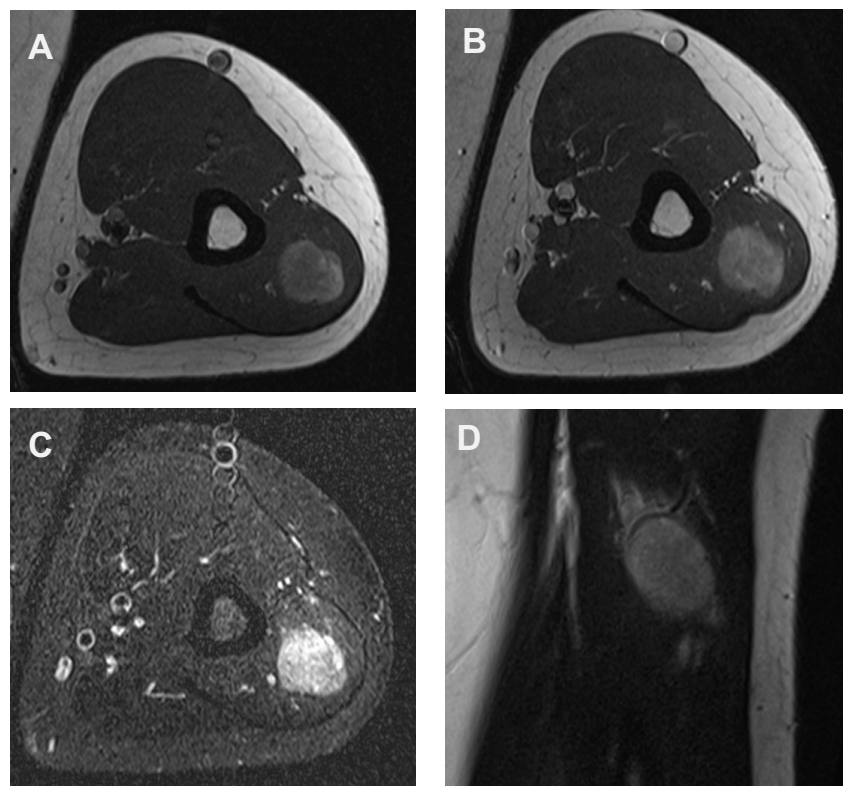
MRI of left upper arm demonstrating enhanced signal in T1 precontrast (A) and postcontrast (B) T1 STIR sequence (C) demonstrating increased signal, T2 image (D) showing intermediate signal. STIR, short τ inversion recovery.
